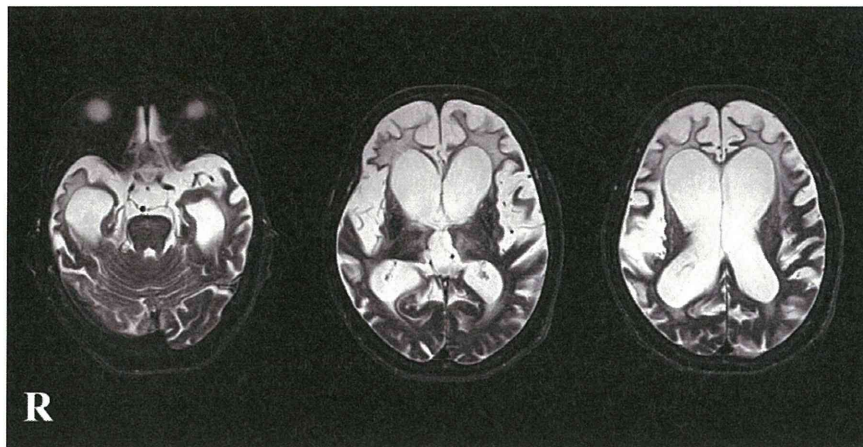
Head magnetic resonance imaging obtained when the present patient was 77 years old, 6.5 years after the onset of dementia. Severe frontotemporal atrophy and lateral ventricular dilatation are apparent. Anterior and inferior horns of the lateral ventricles are markedly dilated. Extensive white matter degeneration of the frontal lobe is also apparent. There is no apparent cerebrovascular lesion. R: right side.
